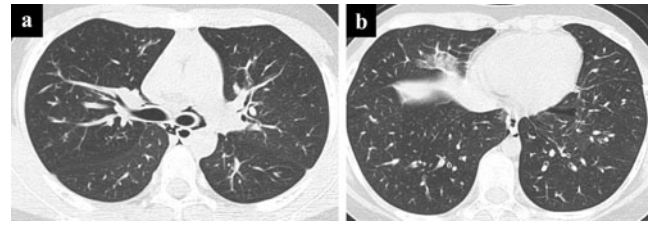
A 10-year-old boy with laboratory-confirmed S-OIV (H1N1) presented to the emergency department with fever, cough, shortness of breath, and nausea. a, b Unenhanced CT shows a pneumomediastinum and patchy GGO in the medial segment of the right medial lobe
